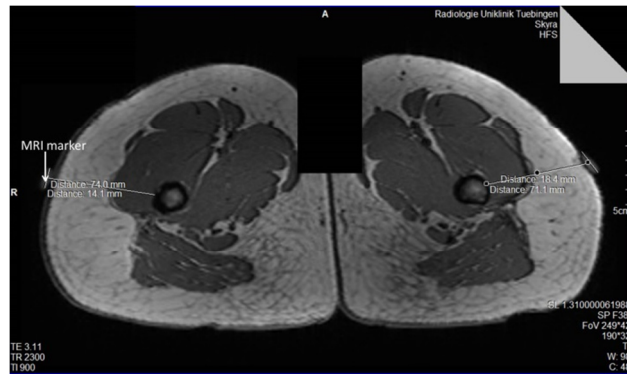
MRI data of one subject with MRI markers.
